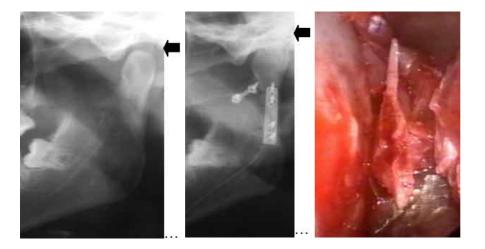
Pre- and postoperative panoramic radiographs and endoscopic view of the fracture site demonstrate the degree of dislocation with shortening of the ascending ramus, and restoration of the vertical height after open reduction and osteosynthesis.
